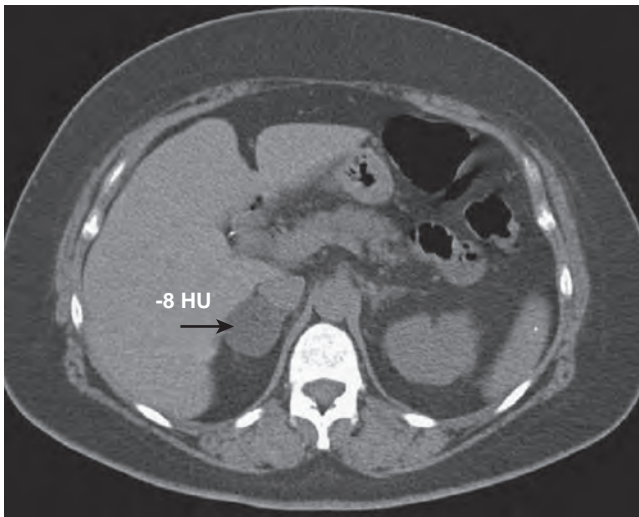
Axial cut of an unenhanced computed tomography scan in a patient with a 3.5-cm, right, lipid-rich adrenal adenoma, demonstrating an attenuation of less than 10 Hounsfield units (HU).
